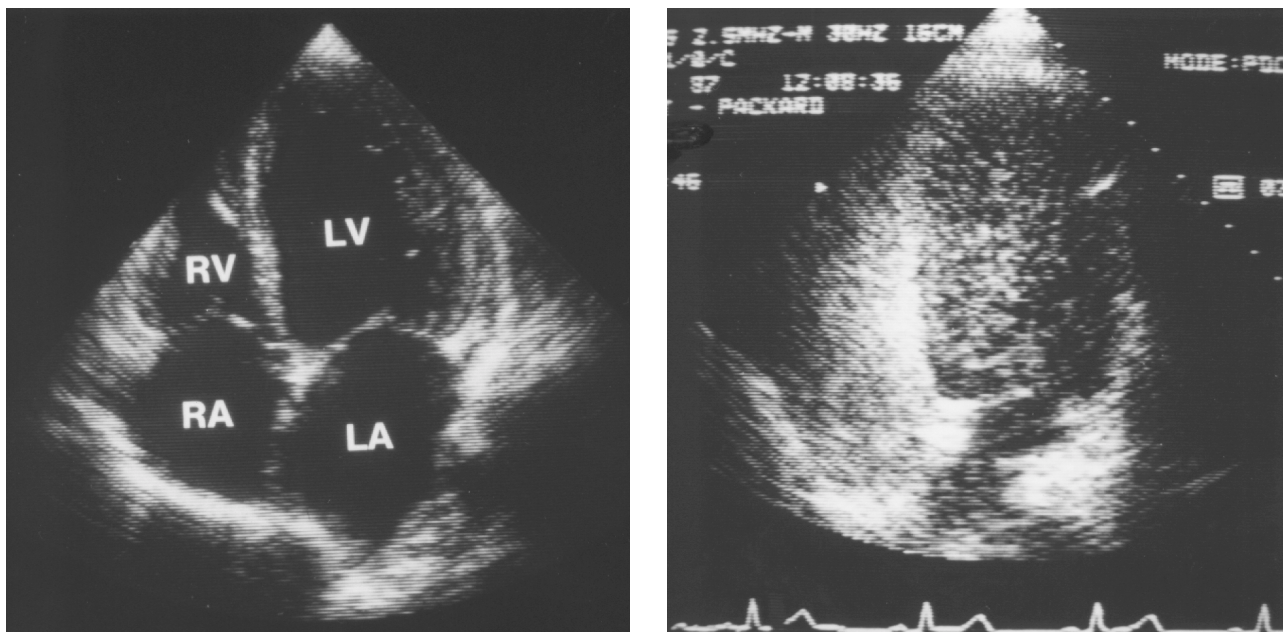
Transthoracic bubble contrast echocardiograph images. On the left, pre-injection, with cardiac chambers labelled. On the right after intravenous injection of bubble suspension in a 48 year old male diver who, a few minutes after a 30 metre 17 minute dive, developed back and epigastric pain, dyspnoea, leg weakness and numbness. He had paraparesis, urinary retention and a T12 sensory level. Bubbles can easily be observed in the left atrium and ventricle.
